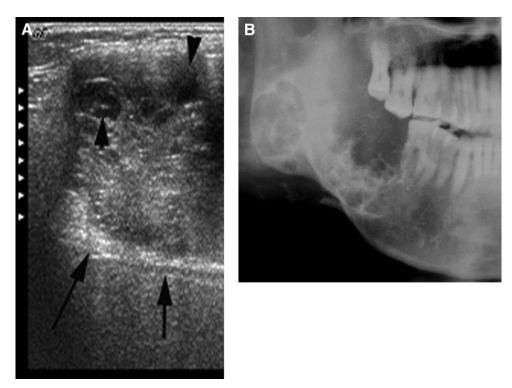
Subject 12: Honeycomb. US (A) showed the compartments (*arrowheads*) of the tumor were small and nearly similar in size and honeycomblike; the boundary (*arrows*) of the tumor is clear. Panoramic radiography (B) showed the compartments were honeycomblike as well.
